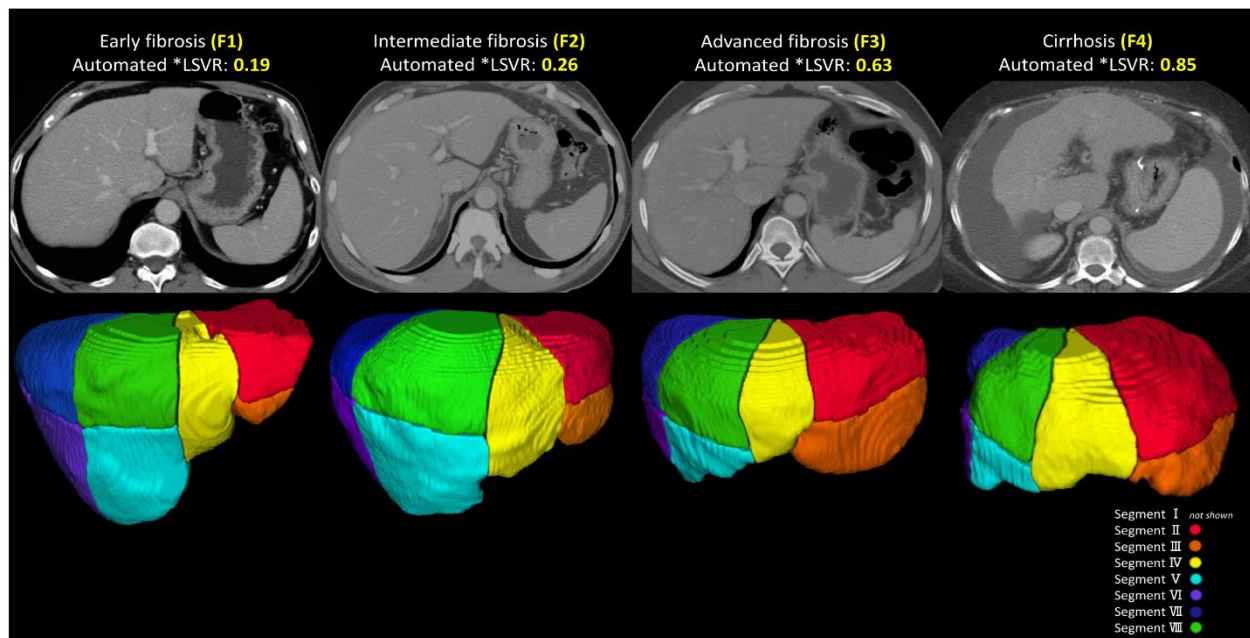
Examples of automated liver Couinaud segment measurements. Automated segmentation of the eight liver Couinaud segments (I-VIII) in four different stages of liver fibrosis according to the Metavir from Dataset1, shown on axial contrast-enhanced CT scans: F1 (54-year-old man with chronic hepatitis C virus [HCV]), F2 (51-year-old man with HCV), F3 (46-year-old man with chronic HCV), and F4 (55-year-old woman with chronic HCV). The liver segmental volume ratio (*LSVR, a ratio of the volume of segments I-III to segments IV-VIII) was larger in higher grades.
